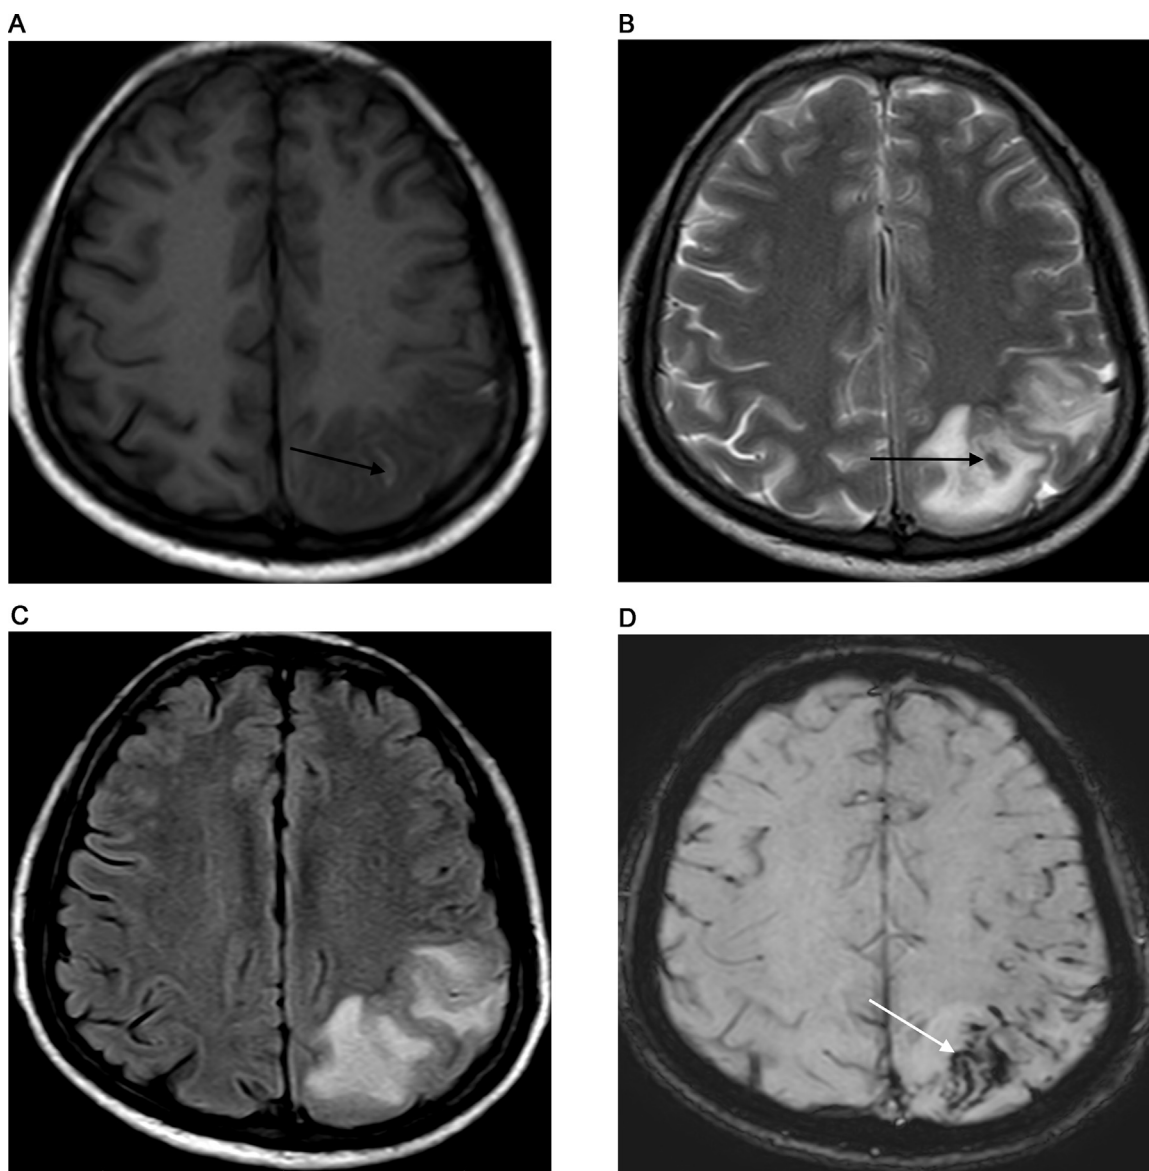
(A) T1 weighted axial MRI image at the level of centrum semiovale showing the ill-defined area of T1 low signal intensity in the left parietal lobe with a patchy area of T1 high signal intensity within (black arrow). (B) T2 weighted axial MRI image of the level of centrum semiovale showing a relatively well-defined area of high signal intensity with a patchy area of low signal intensity within (black arrow) in the left parietal lobe involving both gray and white matter. (C) FLAIR weighted axial MRI image of the level of centrum semiovale showing a relatively well-defined area of high signal intensity in the left parietal lobe involving both gray and white matter. (D) SWI weighted axial MRI image of the level of centrum semiovale showing low signal intensity area of blooming in the left parietal lobe (white arrow).
